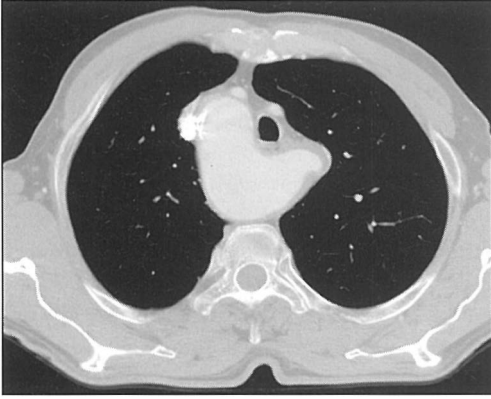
A CT scan showing a right-sided aortic arch and retrotracheal left subclavian artery with a diverticulum at the orifice.
